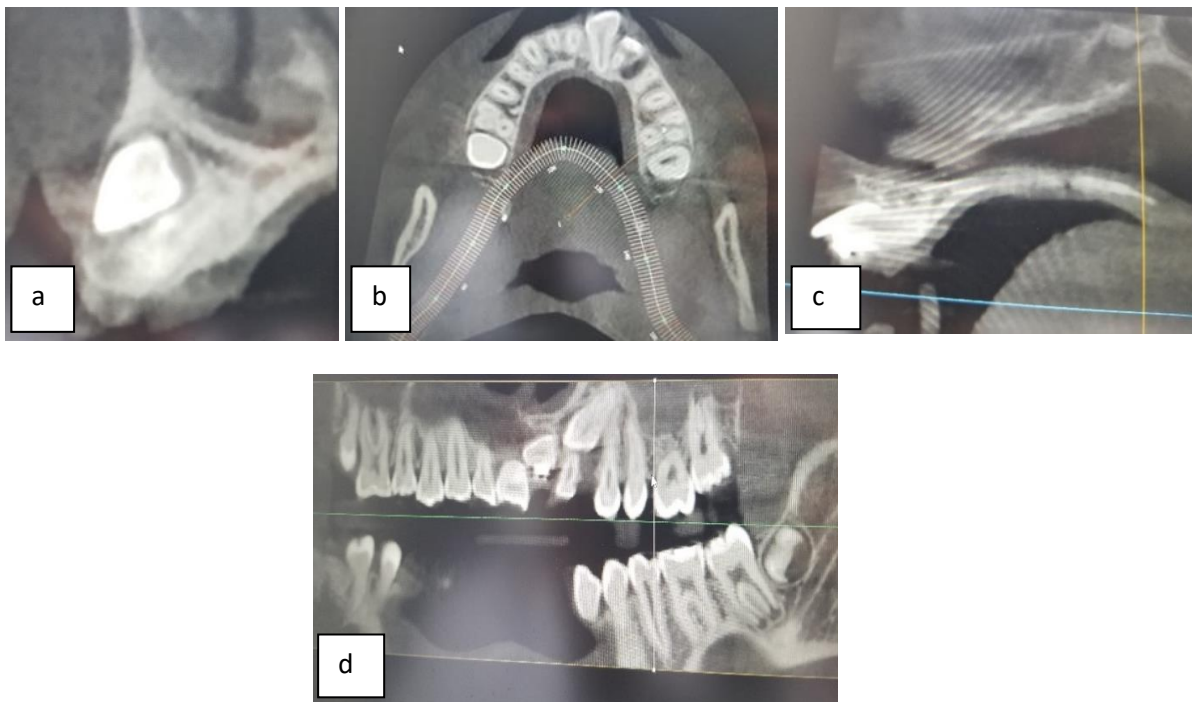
CBCT radiograph of a 13-year-old patient before treatment: a) labial view of partial absence of alveolar bone and periodontal ligament of the central incisor, b) occlusal view of upper dental arch, c) horizontal position of the central incisor and d) suspected lateral incisor root resorption.
